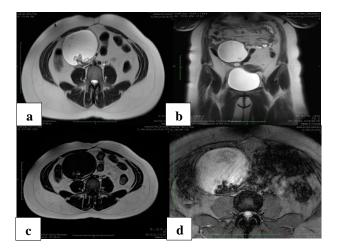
Magnetic resonance images of 30-year-old female with mature cystic teratoma shows (a) axial T2WI shows a cystic lesion in right adnexa with eccentric solid component within, (b) coronal T2WI shows that right ovary is displaced upwards and a cystic lesion seen arising from it, left ovary was normal (not shown), (c) axial T1W Dixon (fat only) images shows few hyperintense foci within corresponding with fat component, and (d) axial GRE images shows blooming foci within the cystic lesion corresponding with calcification.
